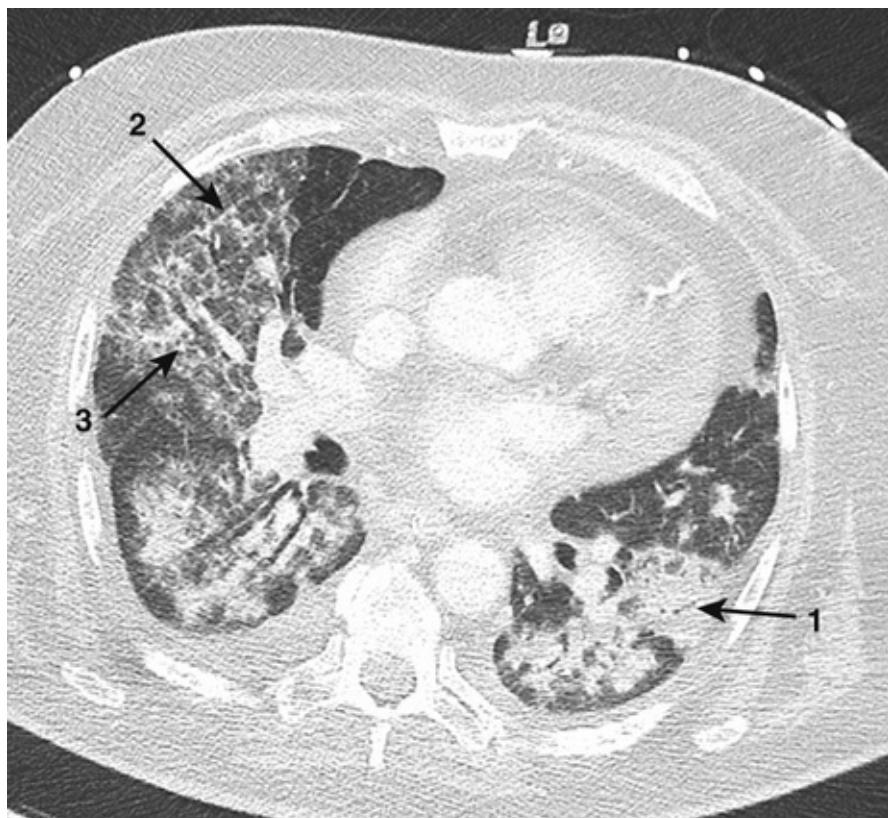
CT lung window settings. This 54-year-old man developed type I respiratory failure as a complication of Gram-negative sepsis. The CT scan shows typical features of ARDS. Notice the bilateral shadowing which includes areas of consolidation (1), ground glass shadowing (2) and interstitial thickening (3). Note that these changes are asymmetric in keeping with a nonpulmonary cause of ARDS.
